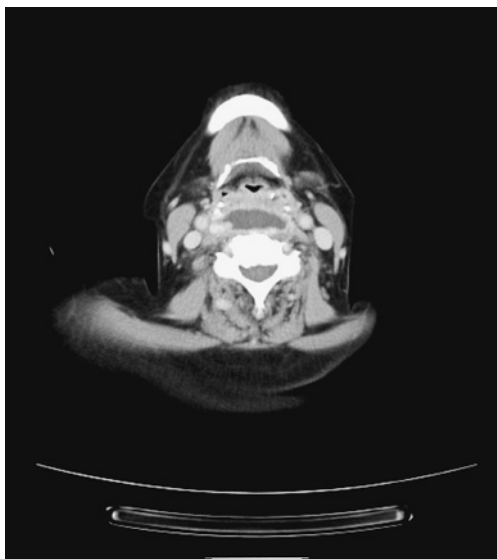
CT findings 19 days after injury.
